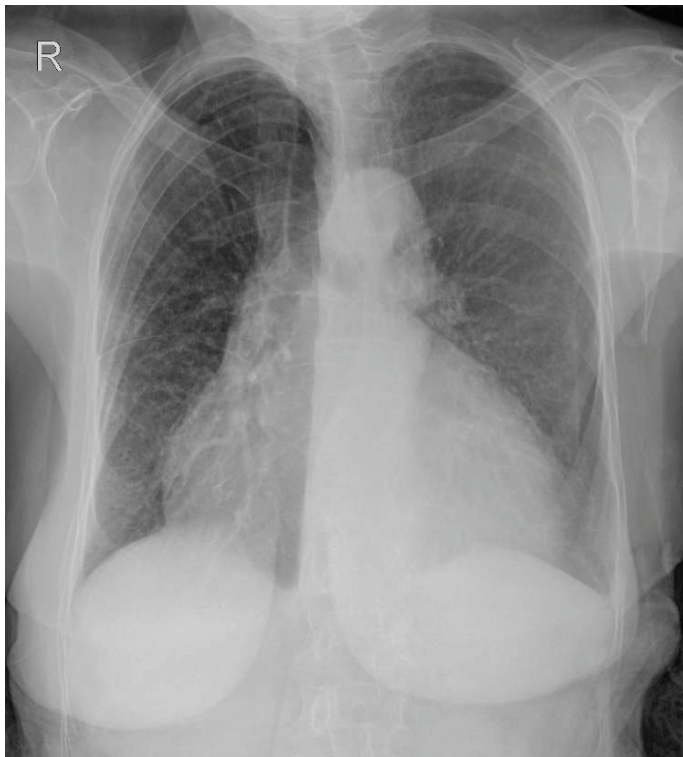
Posteroanterior chest X-ray showed cardiomegaly
